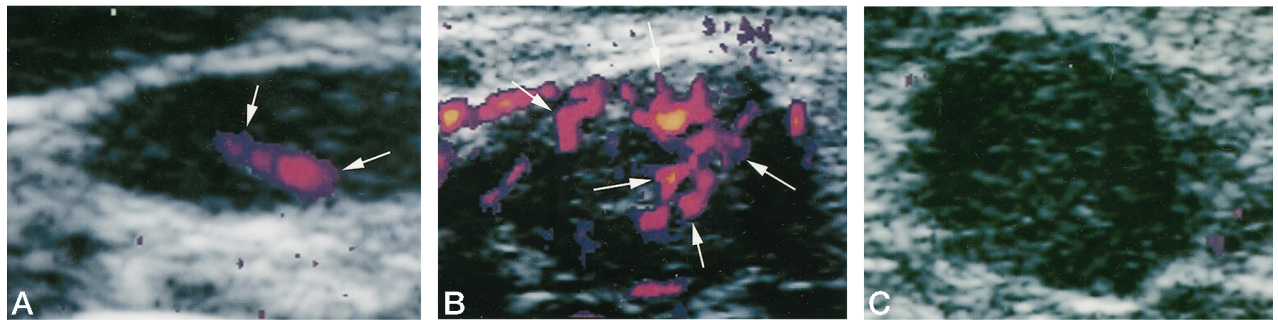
Power Doppler sonographic features of metastatic and nonmetastatic cervical lymph nodes.
